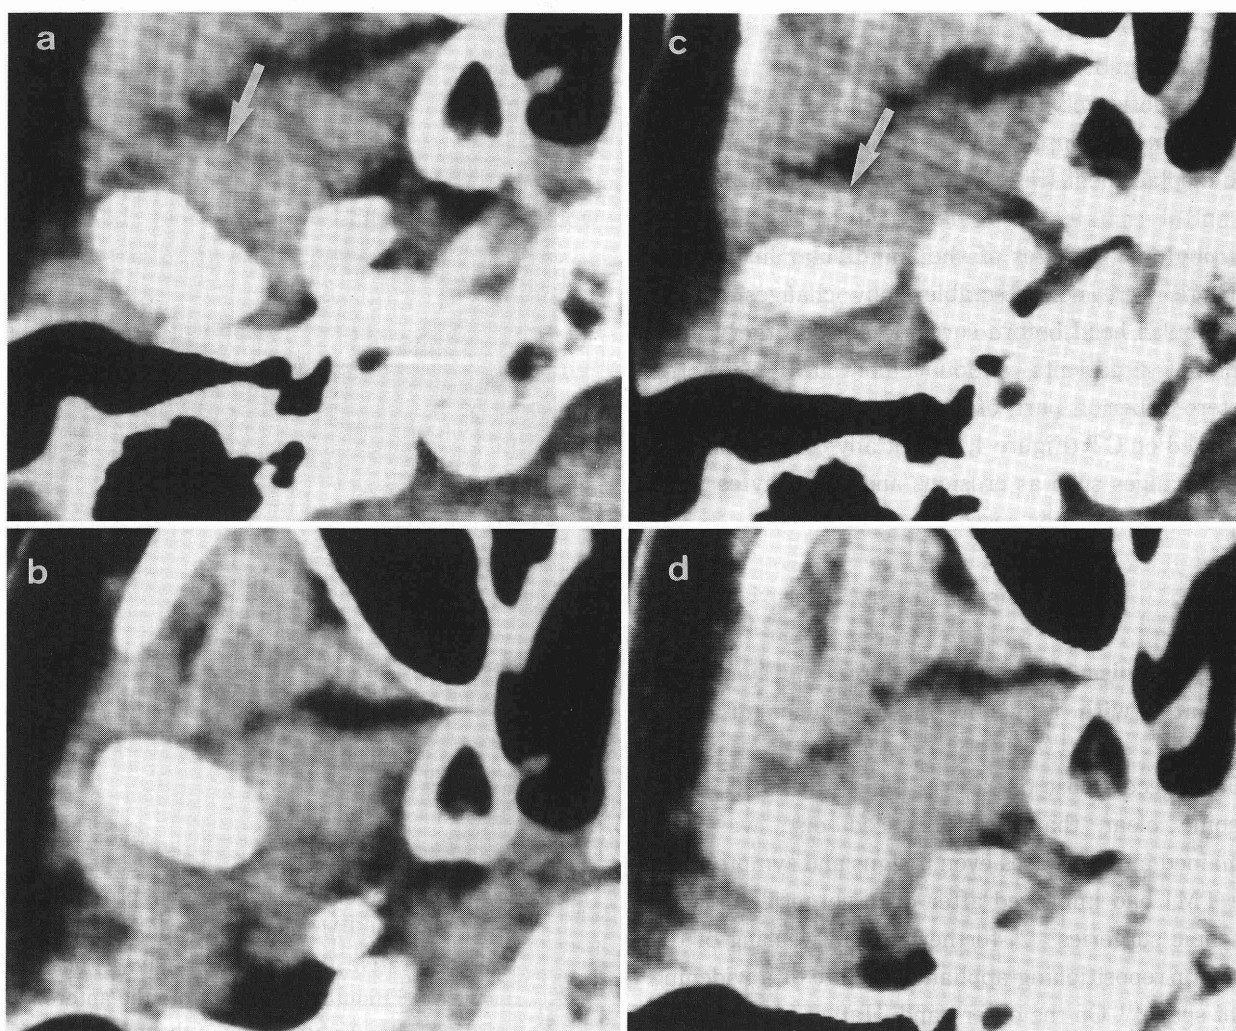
TMJ X-ray computed tomography in axial section (case 2). Pre-(a, b) and post-operative (c, d; post-op. 6 months) images. After IVRO, anteriorly displaced disc (arrow) of right TMJ was unchanged in closed mouth position. In opened mouth position, the disc is reduced (b, d).
